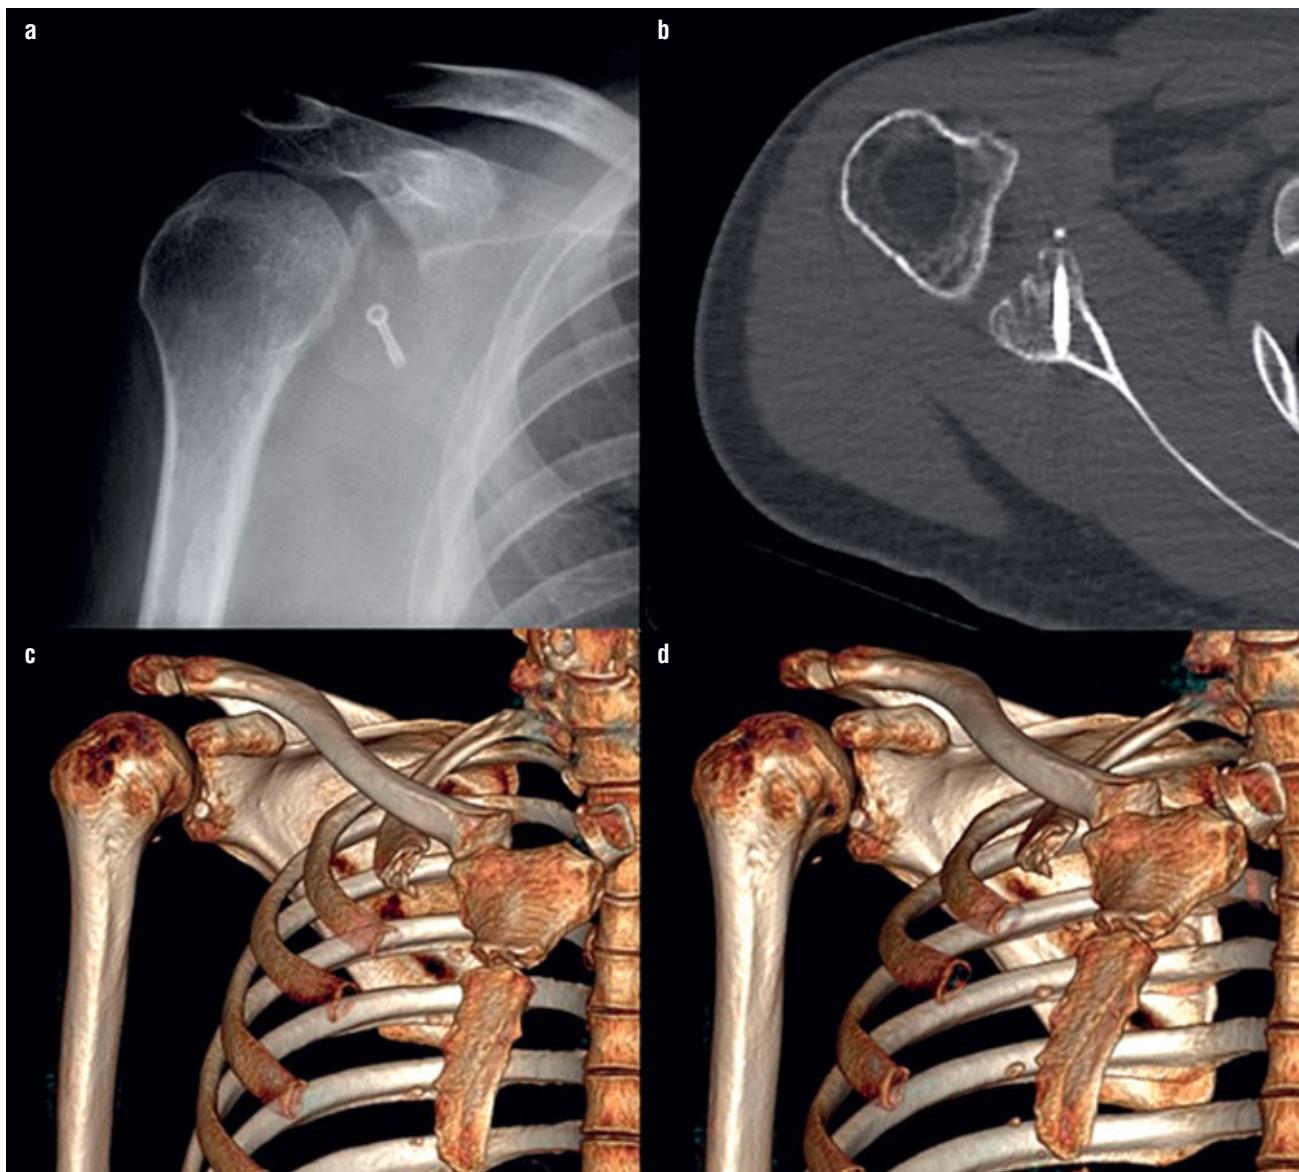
Plain anteroposterior X-ray (a), horizontal (b) CT scan and 3-dimensional CT reconstructions (c, d) 6 months after arthroscopic assisted percutaneous screw fixation showing union of the fracture.
